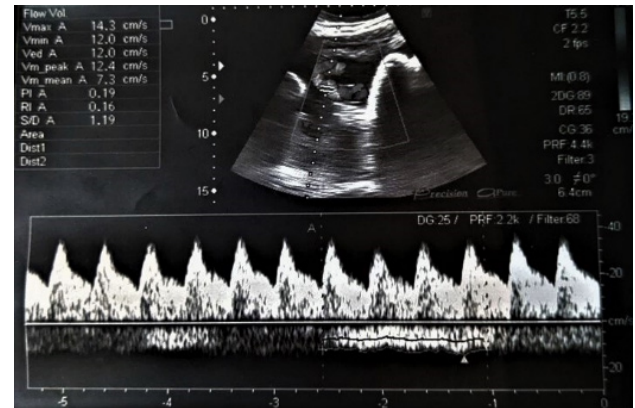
Spectral Doppler of the umbilical vein shows a mean blood flow velocity of 7.3 cm/s.
